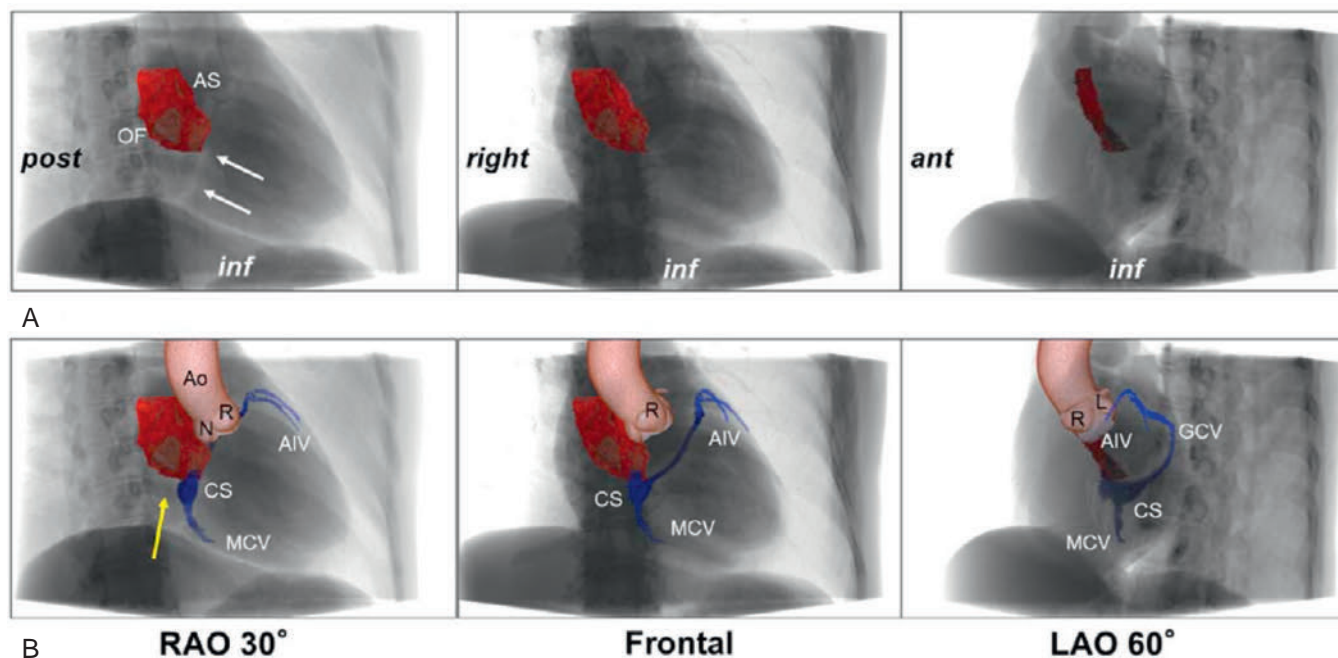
Volume-Rendered Images of the Atrial Septum. (A) The “atrial septum” (AS) is merged with the fluoroscopy-like image. White arrows show the radiolucent band. Note that the oval fossa (OF), interatrial fold, and anteroinferior muscular buttress were reconstructed as one piece (red). Only the OF and muscular buttress are the true AS. (B) The ascending aorta (Ao), coronary sinus (CS), and middle coronary vein (MCV) are added. The yellow arrow indicates where the inferior free wall of the right atrium directly faces the inferior pyramidal space. AIV, Anterior interventricular vein; GCV, great cardiac vein; L, left coronary aortic sinus; LAO, left anterior oblique; N, noncoronary aortic sinus; R, right coronary aortic sinus; RAO, right anterior oblique. (From Mori S, Fukuzawa K, Takaya T, et al. Clinical cardiac structural anatomy reconstructed within the cardiac contour using multidetector-row computed tomography: atrial septum and ventricular septum. *Clin Anat*. 2016;29:342–352.)
